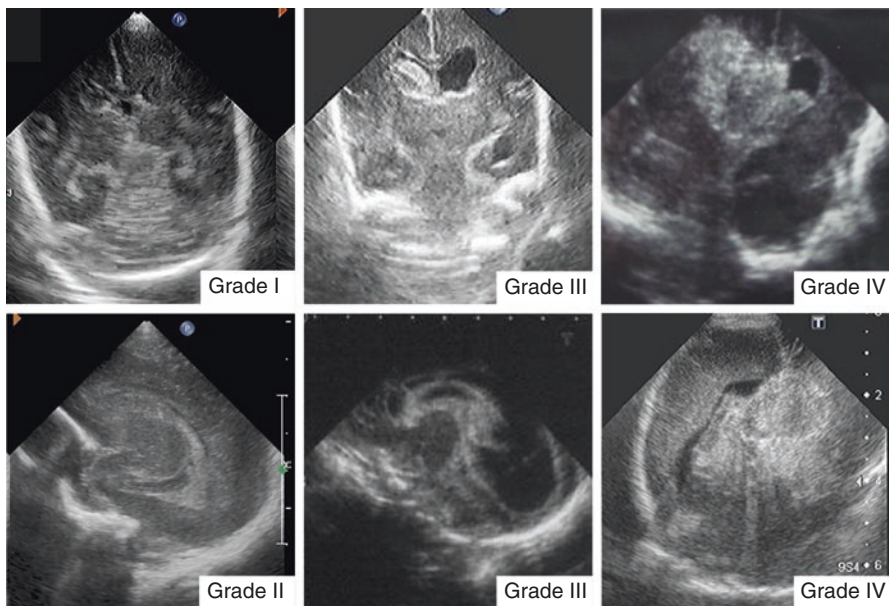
IVH grading. Grade I-IV based on Volpe classification with ultrasound findings
